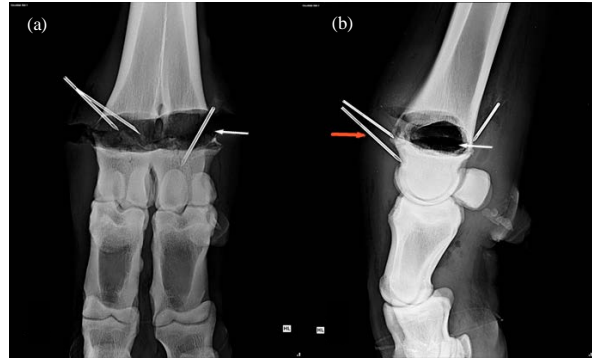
a) Intraoperative dorsoplantar and lateromedial, radiographs of septic physitis case after surgical curettage of the physal lesion. Notice the large radiolucent defect at the site of physis without dislocation of both epiphyses (white arrows). A 18 gauges needles were shown as a marker for location of physal lesion (red arrow)
